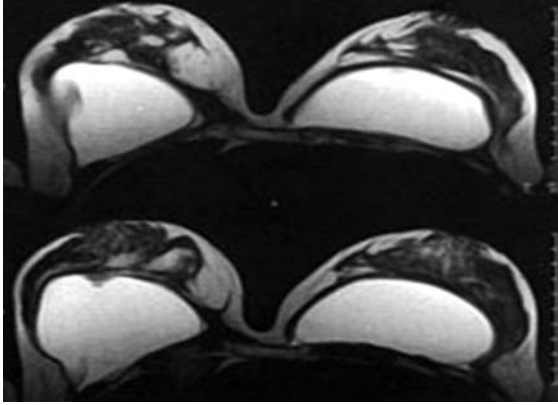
Implant patient—MRI showing cancer breast
